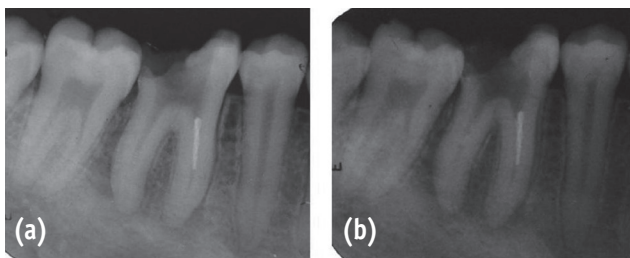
(a) Radiograph showing separated instrument; (b) Radiograph showing dentine surrounding the coronal end of the separated fragment removed with GG drill.
